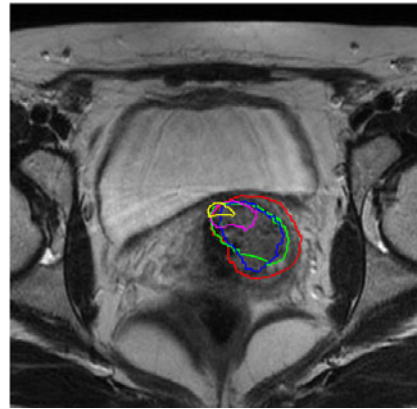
Mapping the detected tumor contours to planning day MRI
